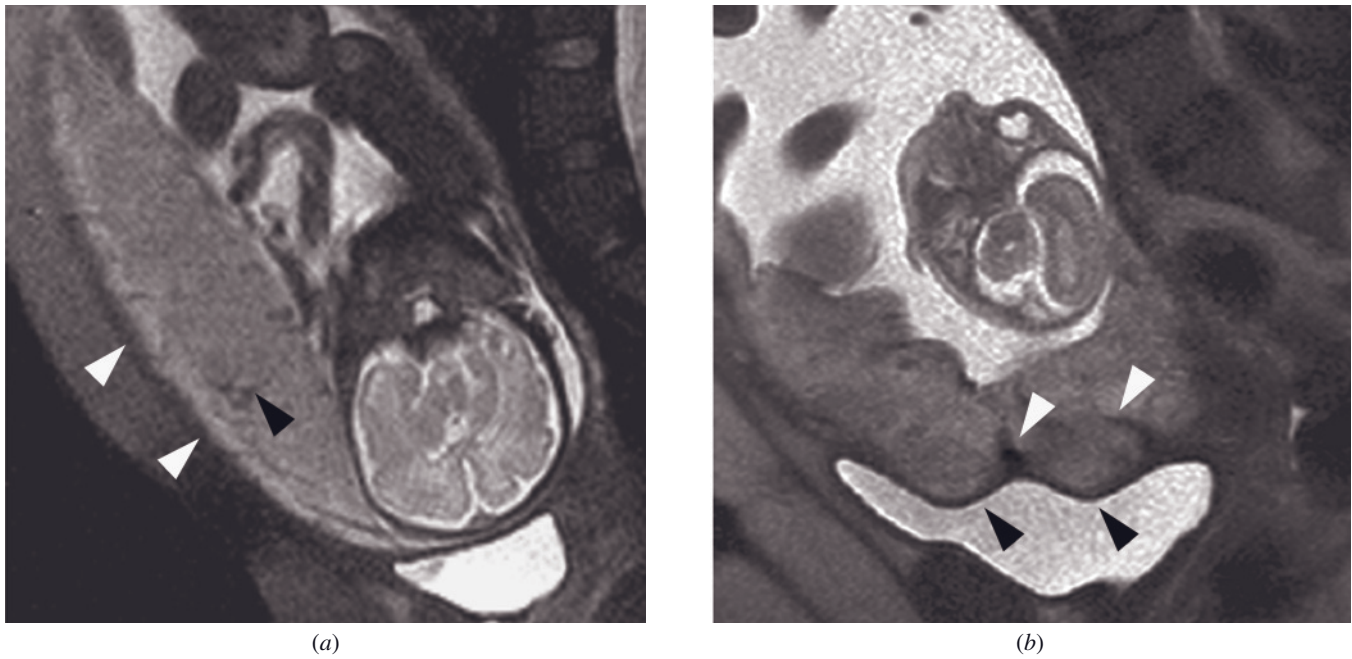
Normal placenta and invasive placenta, second trimester. Sagittal T2-weighted SS-ETSE images in 2 patients show a normal placenta (*a*) and an invasive placenta (*b*). The normal placenta (*a*) has a smooth outer contour (white arrowheads, *a*) and homogeneous moderately high signal intensity. Dark vessels (black arrowhead, *a*) can be seen coursing through the placenta. In contrast, the invasive placenta (*b*) is more heterogeneous, with a lobulated outer contour (black arrowheads, *b*) and dark bands (white arrowheads, *b*) that do not represent vessels. Placenta percreta was found at surgery.
